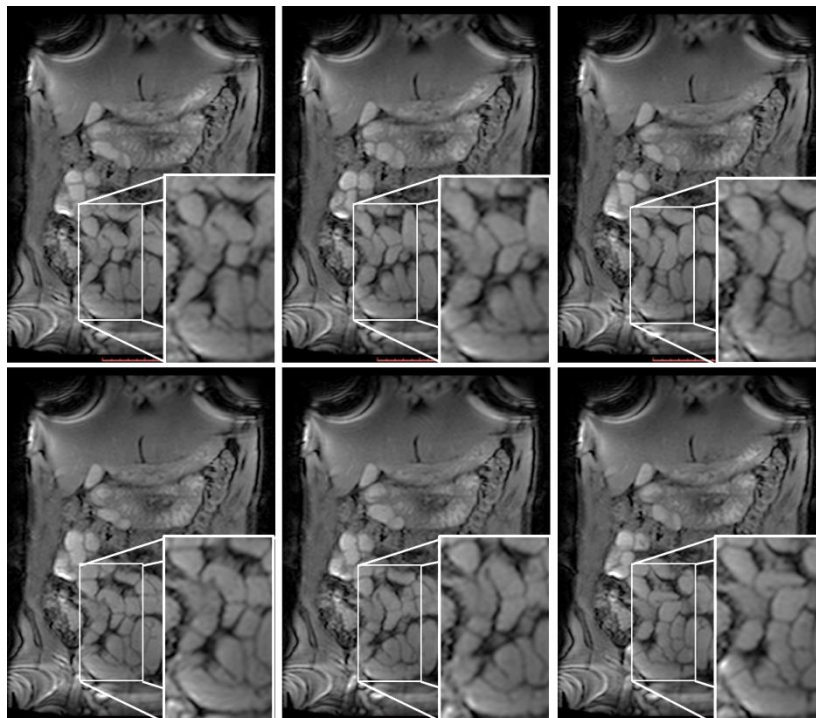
Example of Dynamic MRI of the small bowel in a healthy subject. In each time point a zoom on a small bowel region is shown to highlight bowel displacements related to peristalsis over time.
